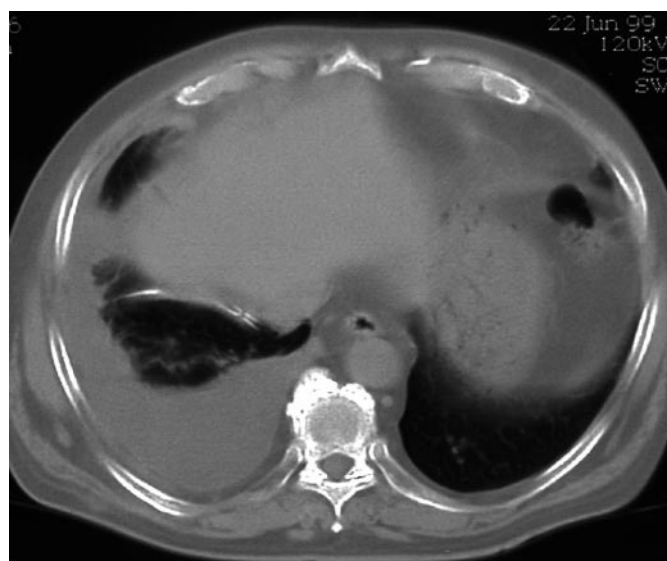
Chest CT of a patient with a PC in place.
